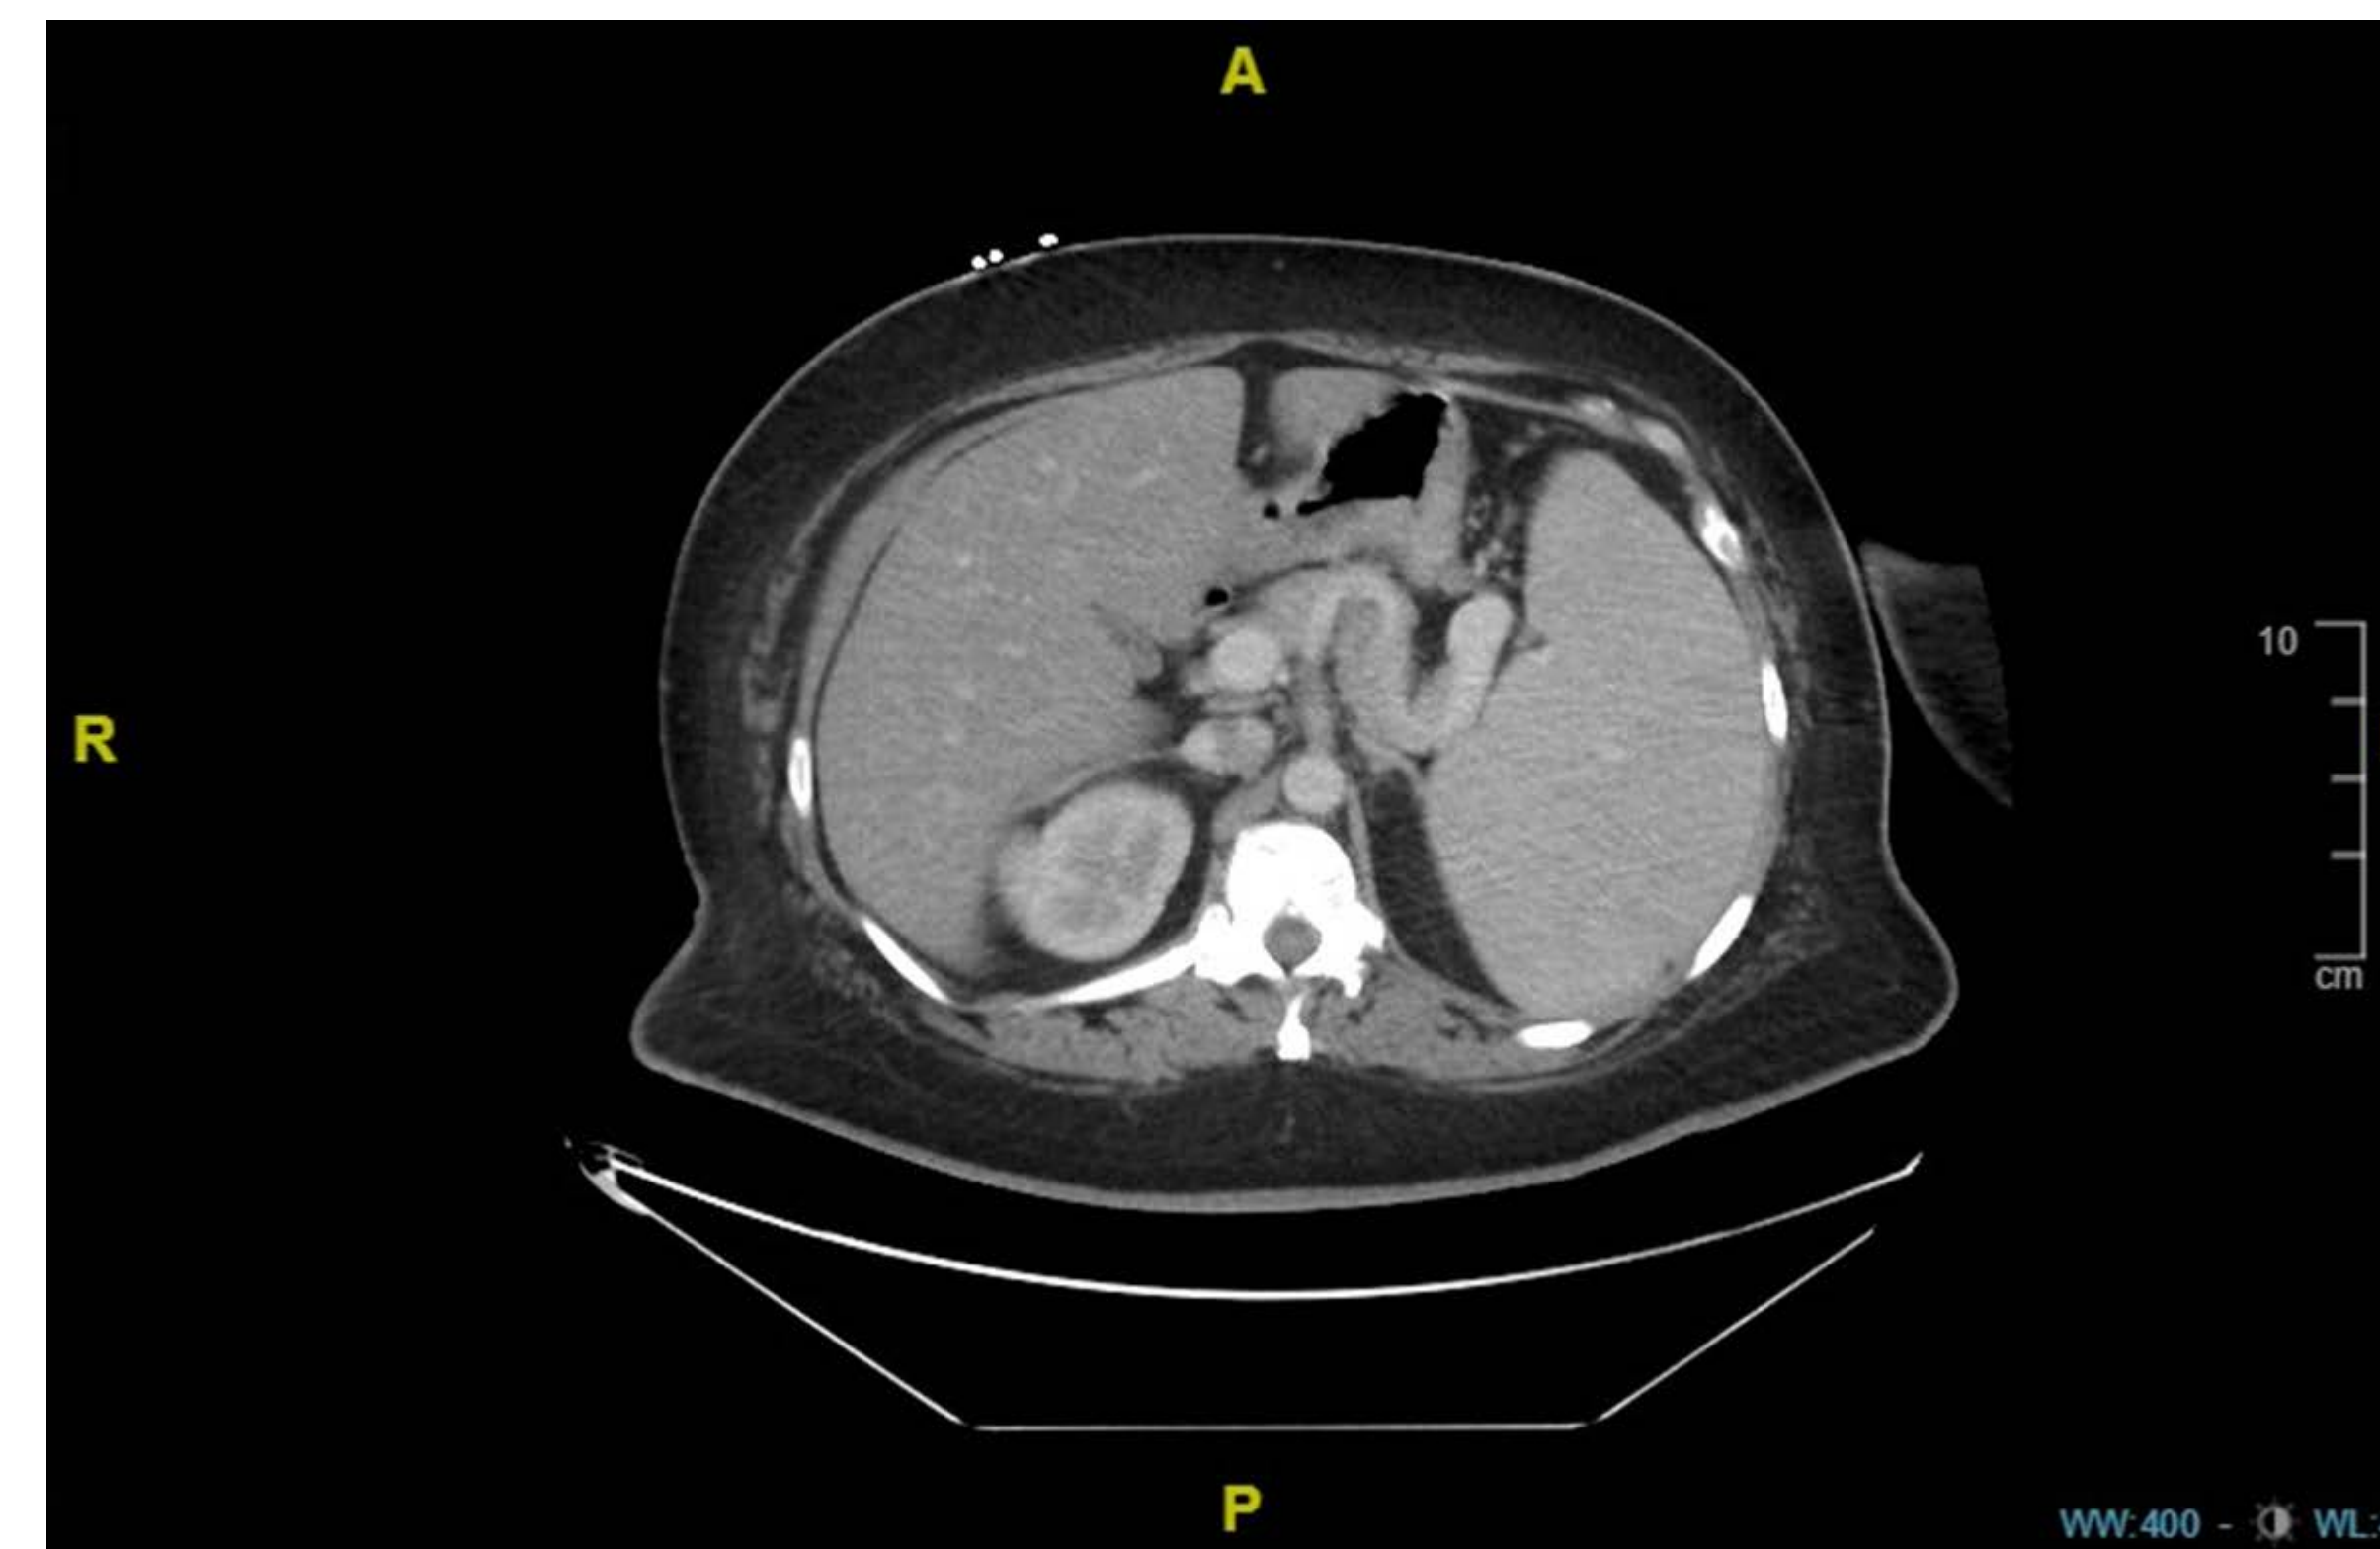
CT abdomen w/o contrast notable for hepatomegaly and splenomegaly (18cm)
